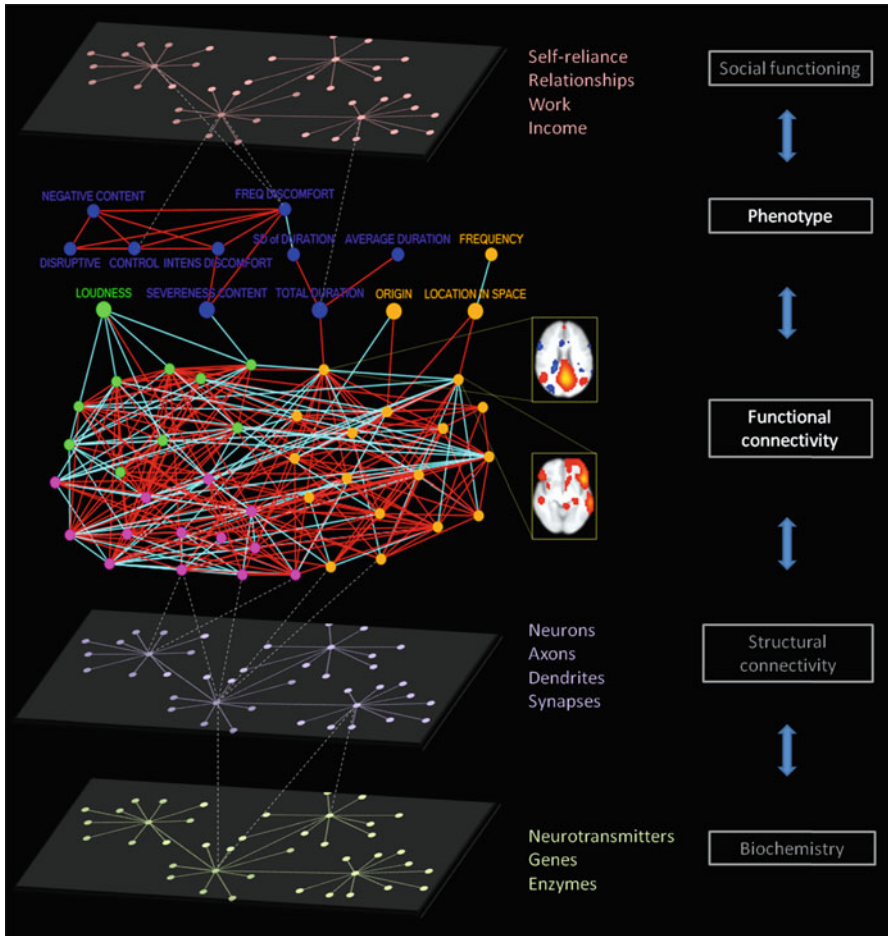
Coupled network graphs of functional connectivity in relation to a network structure of symptoms of patients who experience verbal auditory hallucinations (Looijestijn et al., data in preparation). Measured data are shown in color. Functional connectivity: network of neurophysiological data (independent components of functional magnetic resonance signal). Phenotype: subjective symptoms as rated with the aid of a questionnaire (PSYRATS) and registered hallucination timings during magnetic resonance imaging. Hypothetical additional levels of organization are shown in gray and can be added to the model at later stages. Based on knowledge of the relationships between the various factors that relate to the origin and phenomenological expression of hallucinations, therapeutic intervention foci can be predicted at each level of network organization (e.g., medication, transcranial magnetic stimulation, psychotherapy, work, etc.)
